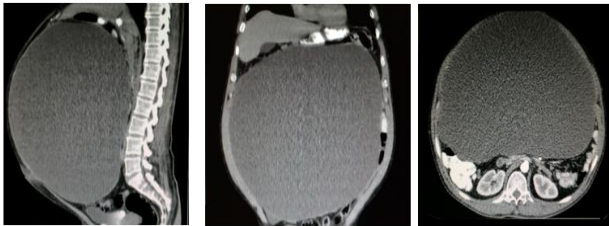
Computed tomography of the abdomen, sagittal, coronal and axial section with evidence of simple mesenteric cyst, encapsulated, without data of invasion to adjacent structures, without data suggestive of tumoral activity.
